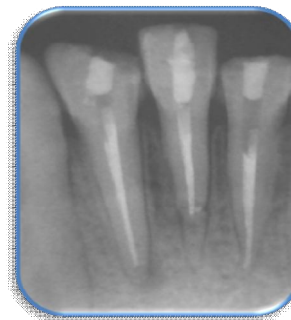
follow up radiography (1 year)
